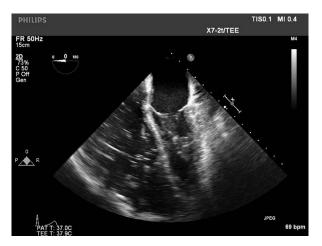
Transesophageal echocardiography, mid-esophageal fourchamber still image demonstrating right ventricular (RV) dilation and paradoxical ventricular septal motion characteristic of RV failure. Artifact from intravenous injection is seen in the RV.
